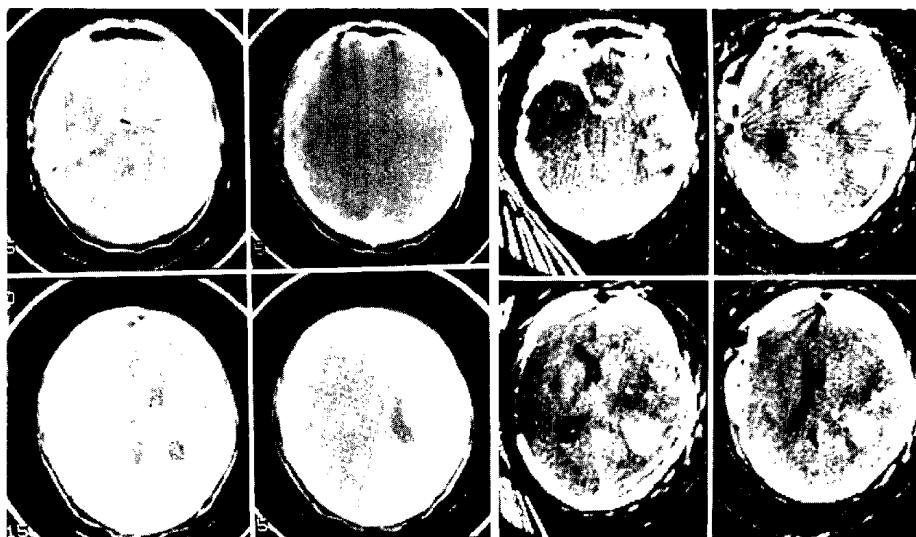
Subdural and intracerebral hematomas. 52-year-old male. A characteristic crescent appearance of subdural hematoma with severe midline shift is seen on CT, taken about 4 hours after trauma (A). An emergency operation was done and the subdural hematoma was evacuated. Postoperative CT, taken after 13 hours after trauma, shows no subdural hematoma but large intracerebral hematomas on the right side (B).
